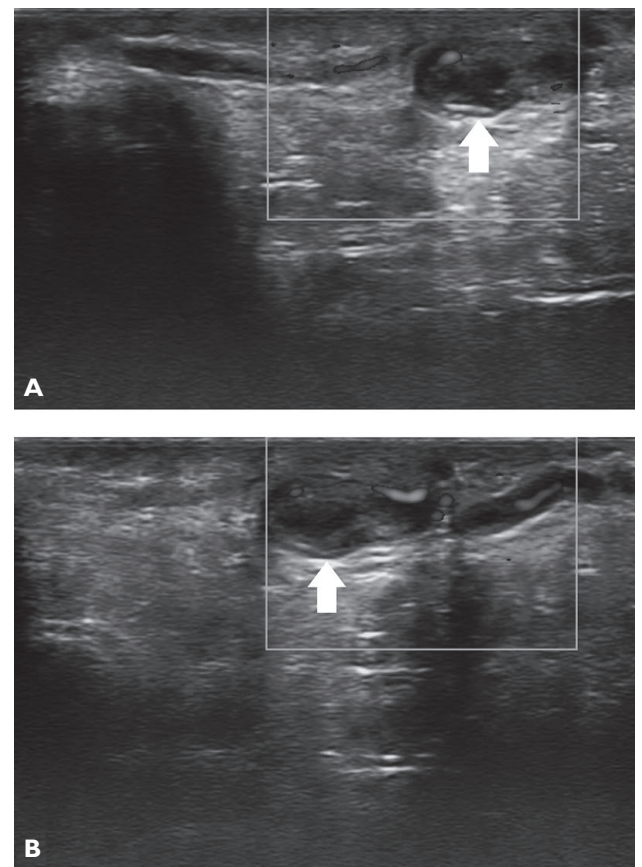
Ultrasonography of the thumb demonstrating thrombosis of the princeps pollicis artery of the thumb (white arrow).
